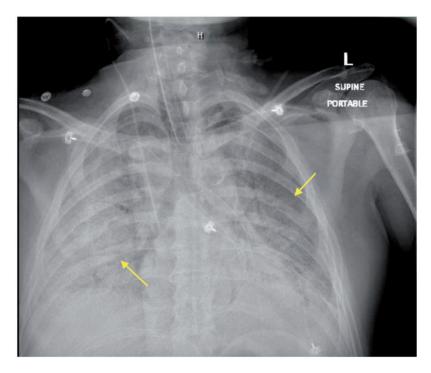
Frontal chest radiograph on admission day 12, performed after intubation and cardiac arrest 2.5 hours after completion of plasma transfusion. The radiograph showed the endotracheal tube 4.9 cm above the carina, the right internal jugular central venous line tip in the superior vena cava, no pneumothorax, diffuse infiltrates/consolidations bilaterally (right greater than left). These findings were significantly worse than those observed in the morning; the pneumomediastinum was less conspicuous because of worsening lung disease.
